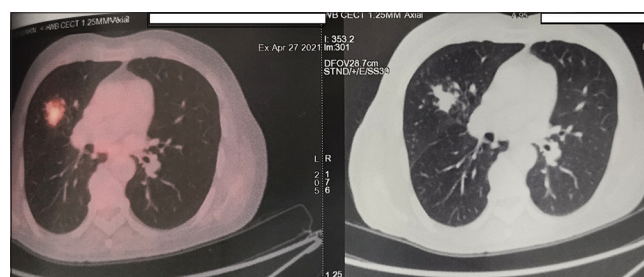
Positron emission tomography-computed tomography showing the hypermetabolic nodule with irregular margins
